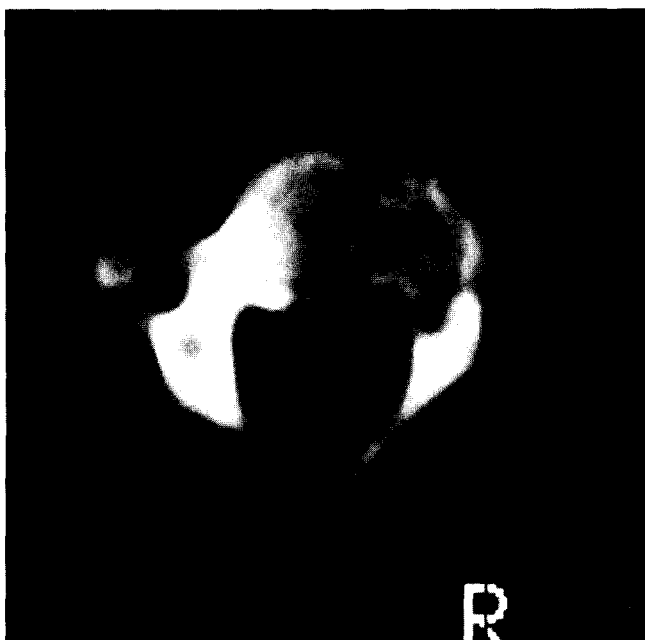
Computed tomography scan through the C-2 vertebra showing expansile mass in the right pedicle and body. Superior images (not presented) showed involvement of the odontoid process.
